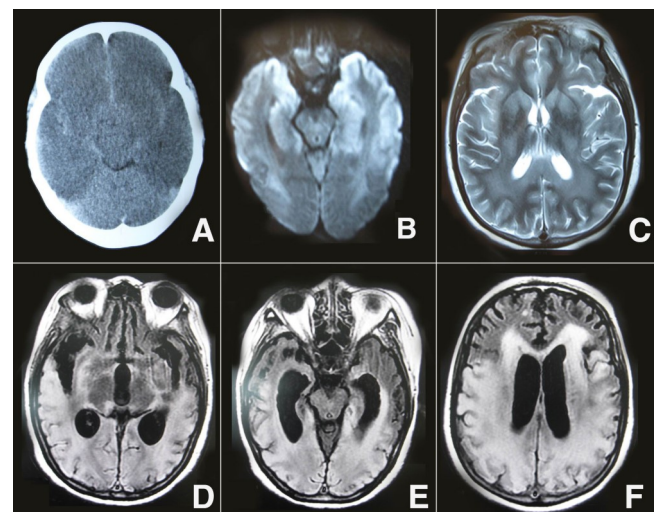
A. Brain CT showed a whole cerebral brain swelling, caudal transtentorial Herniation, and microhemorrhages in the intercerebral and subarachnoid; B. DWI showed extensive lesions of the bilateral middle, hippocampus and the gray matter of the frontal and temporal cortices; C. brain MRI T 2-weighted imaging showed bilateral symmetric high signal intensity in the caudate, putamen, thalami, occipital, parietal cortices and subcortical white matter; D-F. On follow-up MRI 60 days later, FLAIR showed cortical, subcortical white matter, and periventricular white matter confluent hyperintense lesions in the bilateral temporal, parietal, and occipital regions, and enlarged ventricles.
